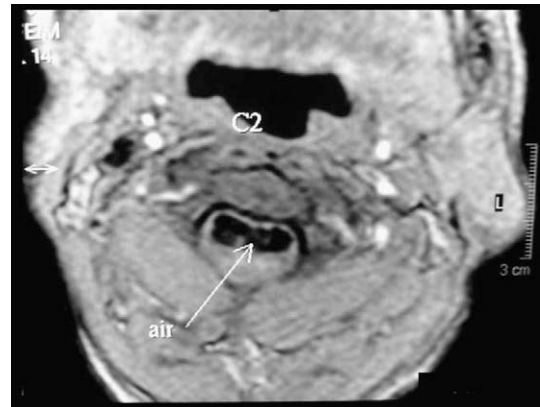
Axial post-contrast T1-weighted MRI at the C2 vertebra showing intradural air.
